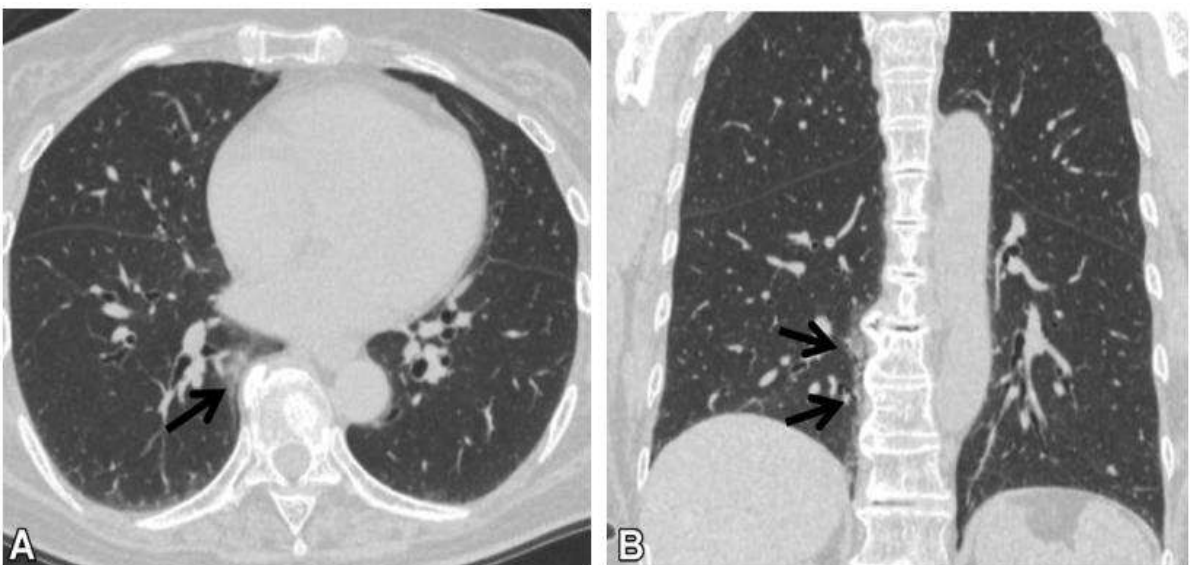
The osteophyte-related lesion in a 72-year-old woman with no respiratory symptoms. (A) Axial CT image shows ground-glass abnormality adjacent to an osteophyte (arrow) (B) Coronal CT image shows the craniocaudal alignment (arrows) of the abnormality²
